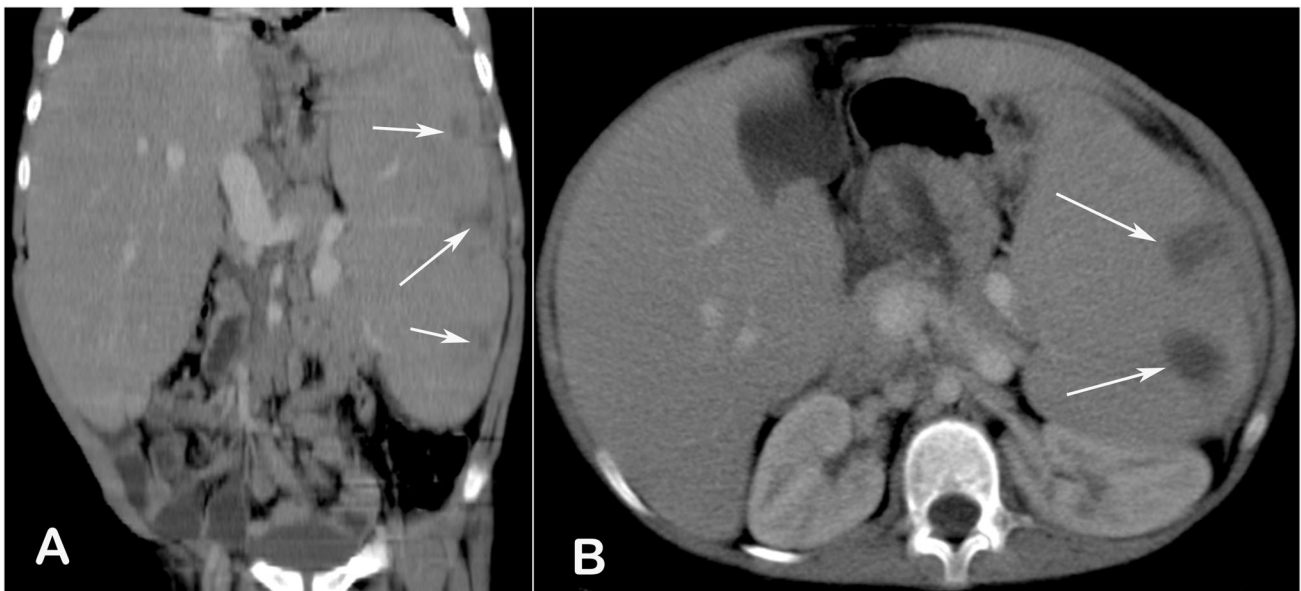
Contrast-enhanced reformatted coronal (a) and axial (b) CT images show *marked* enlargement of the liver and spleen. Note also hypodense nodular lesions in the spleen, which although nonspecific, are characteristic findings of Niemann–Pick disease
